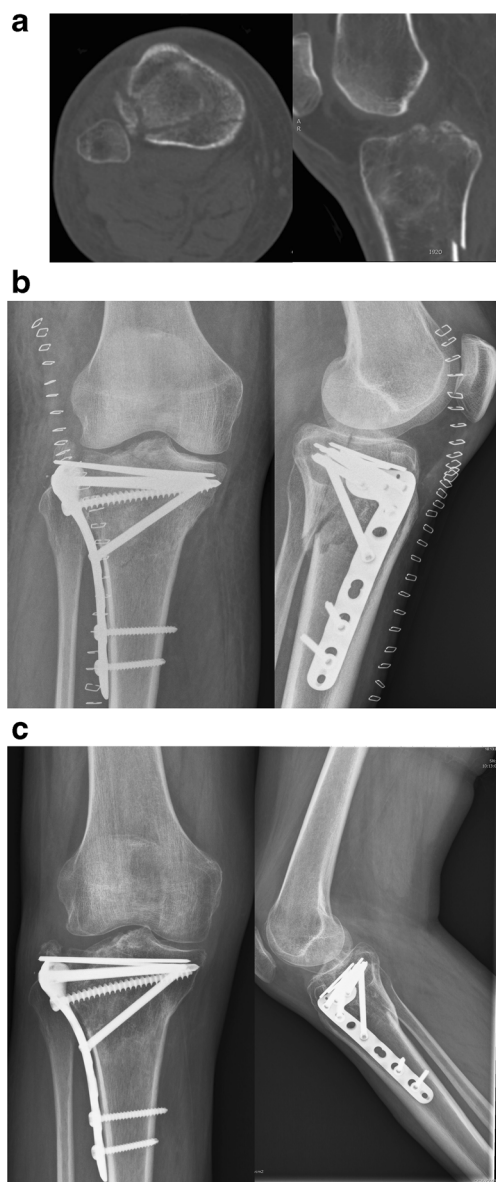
Demonstrative case with poor functional outcome. a Pre-operative CT-images showing a three-column tibial plateau fracture. b Post-operative coronal and sagittal X-rays after anterolateral plating and the use of additional K-wires. c Coronal and sagittal X-rays at 10 months follow-up
